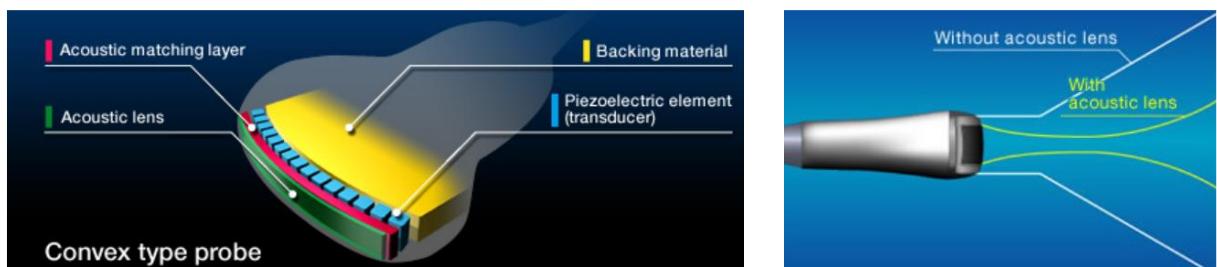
Linear array ultrasound transducer with acoustic matching and acoustic lens. The right picture shows the beam with or without the acoustic lens.
